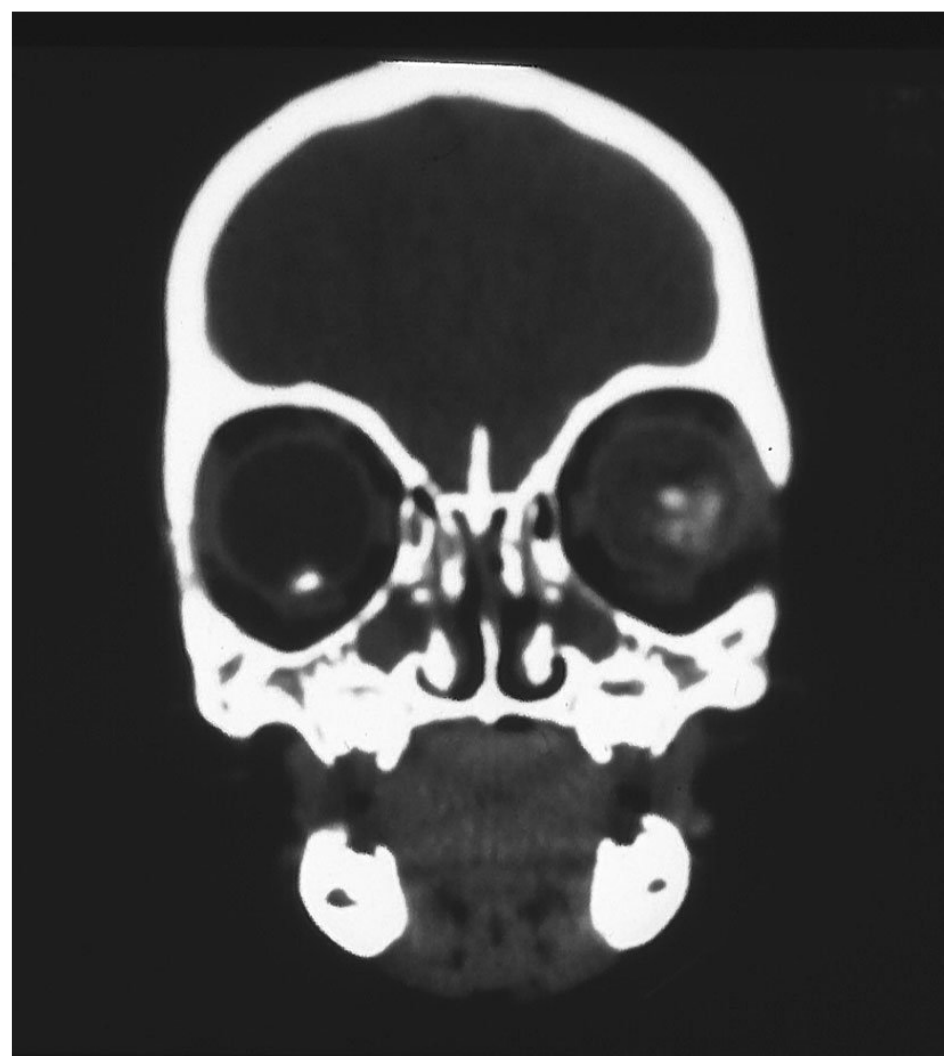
Computed tomography (CT) scan demonstrating a large retinoblastoma in left eye and a small, previously undiagnosed retinoblastoma in the right eye.
